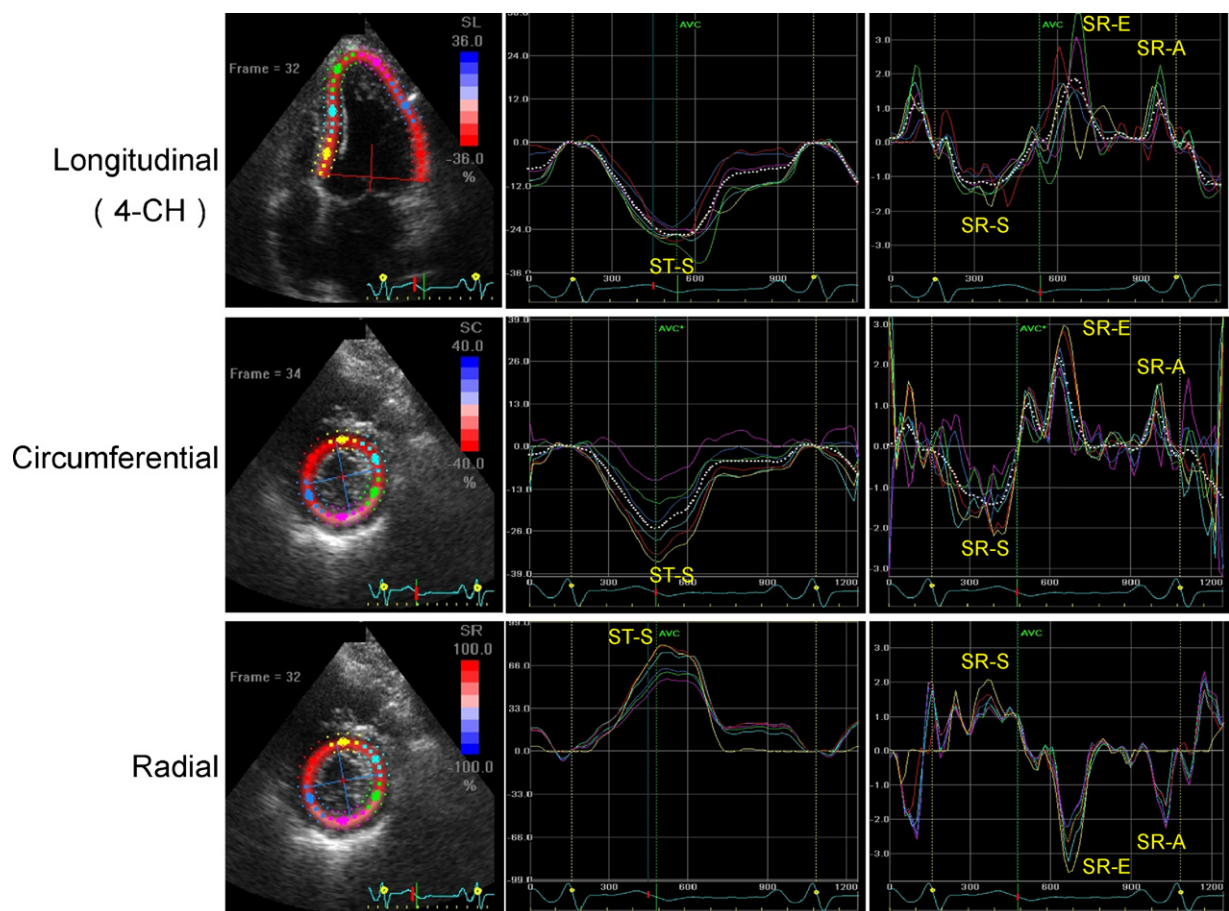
Longitudinal, circumferential, and radial strain and strain rate curves of left ventricular walls using two-dimensional speckle-tracking imaging in a healthy subject. 4-CH, apical 4-chamber view; ST-S, peak systolic strain; SR-S, peak systolic strain rate; SR-E, peak early diastolic strain rate; SR-A, peak strain rate during atrial systole.
